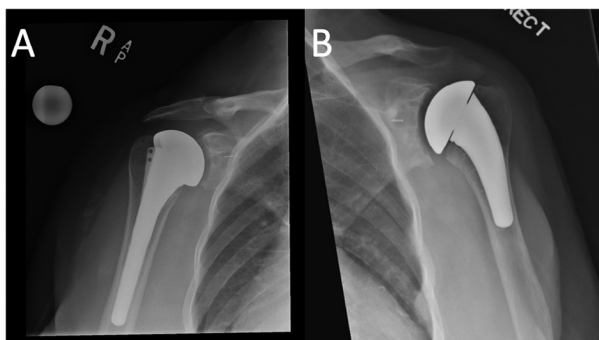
Bilateral shoulder radiographs showing right shoulder with standard long-stem humeral implant (A) and left shoulder with mini-stem humeral component (B).
